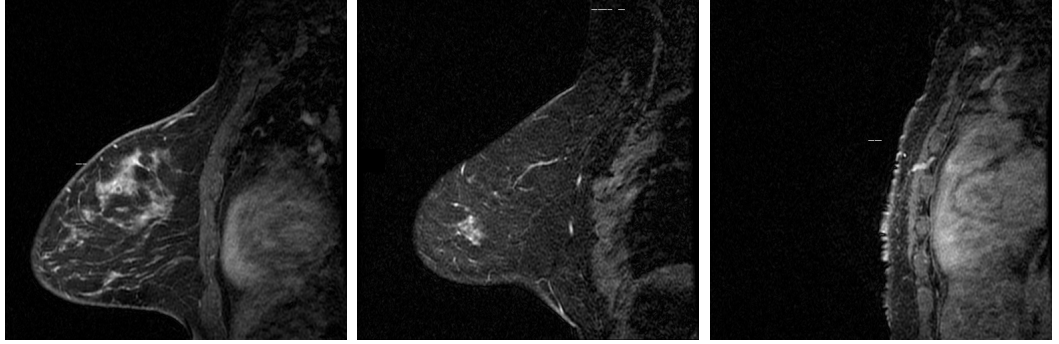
Breast Magnetic Resonance Images (BMRI) in the Sagittal plane orientation
